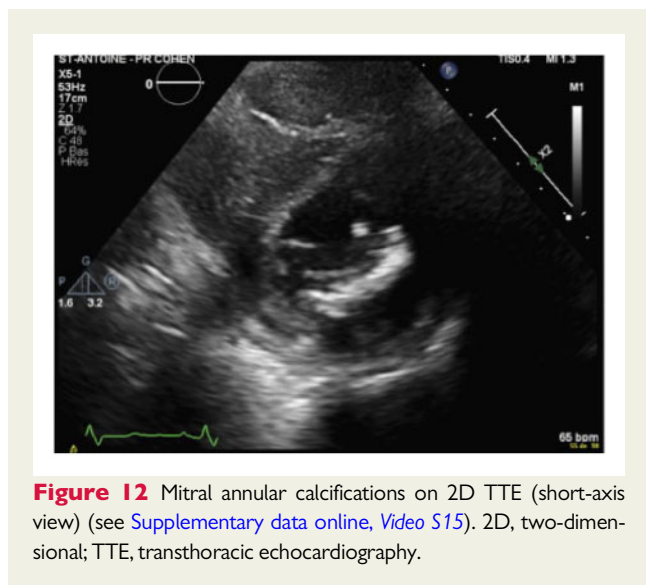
Mitral annular calcifications on 2D TTE (short-axis view) (see [Supplementary data online, Video S15](#)). 2D, two-dimensional; TTE, transthoracic echocardiography.
